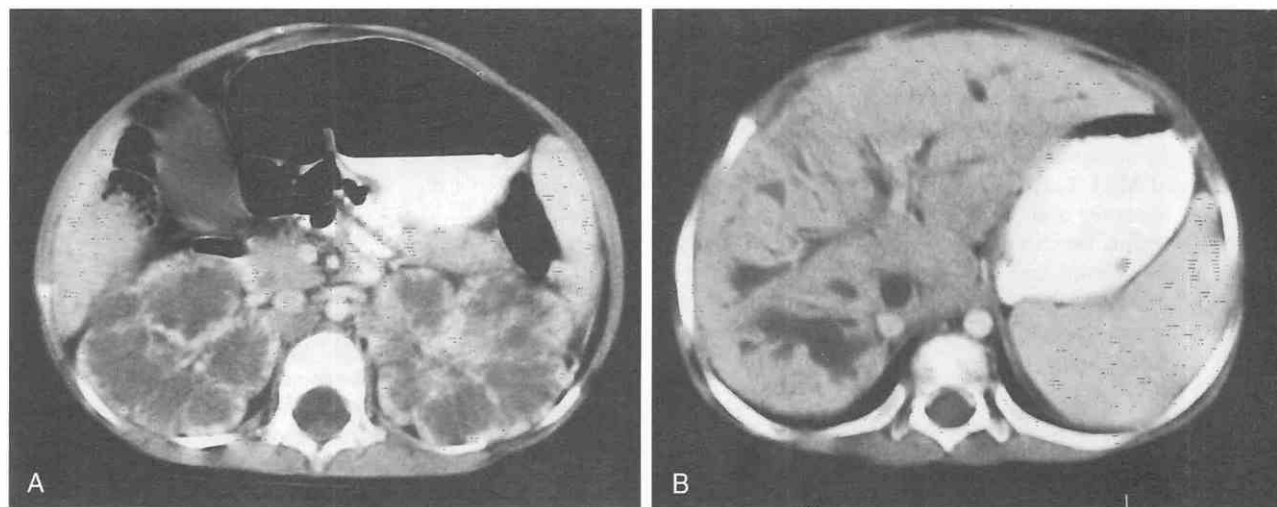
Autosomal recessive polycystic kidney disease with hepatic fibrosis in a 3-year-old girl who presented with severe hypertension. A, Contrast-enhanced CT axial image through the kidneys. Both kidneys are very enlarged. Dilated and ectatic collecting tubules appear as fusiform cystic structures within the very enlarged medullary pyramids. At the periphery of the kidney, the cortex is thinned and enhances inhomogeneously. B, Contrast-enhanced CT axial image through the liver. The intrahepatic bile ducts are diffusely dilated and ectatic.
